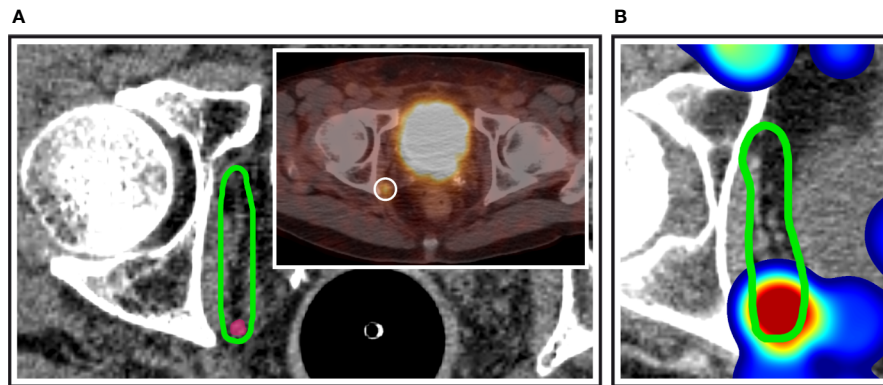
Obturator nodes at the posterior edge of the NRG consensus CTV. (A) Exemplary patient case with a PSMA-avid nodal metastasis (inset) right at the posterior edge of the NRG obturator level. (B) Corresponding anatomic location in the independent mapping analysis showing a high-probability hotspot near the posterior edge of the NRG CTV recommendation.
